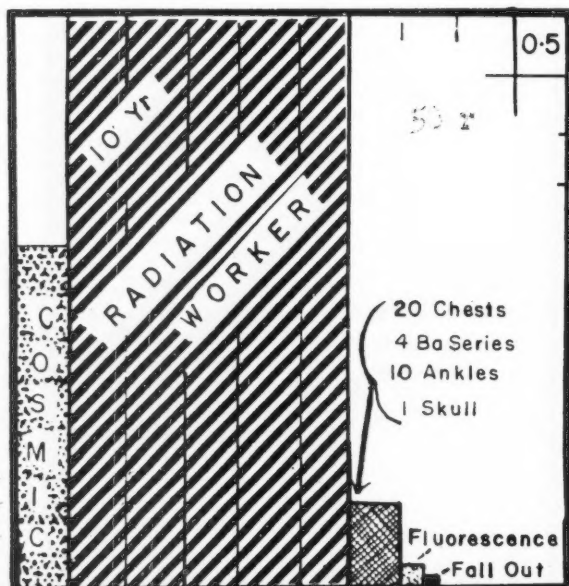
Permissible individual genetic dose. Note the contribution by cosmic radiation, x-ray examinations as listed, a fluorescent dial, and fallout.
